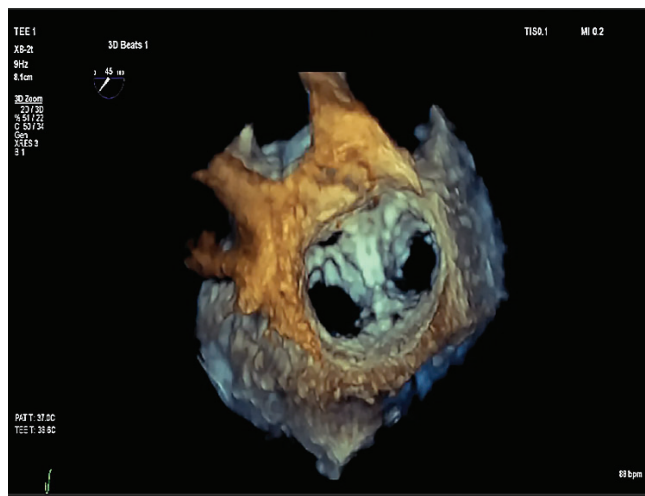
Postprocedural 3D transoesophageal echocardiography en face view of the mitral valve, demonstrating the final clip position and the resulting double-orifice configuration
